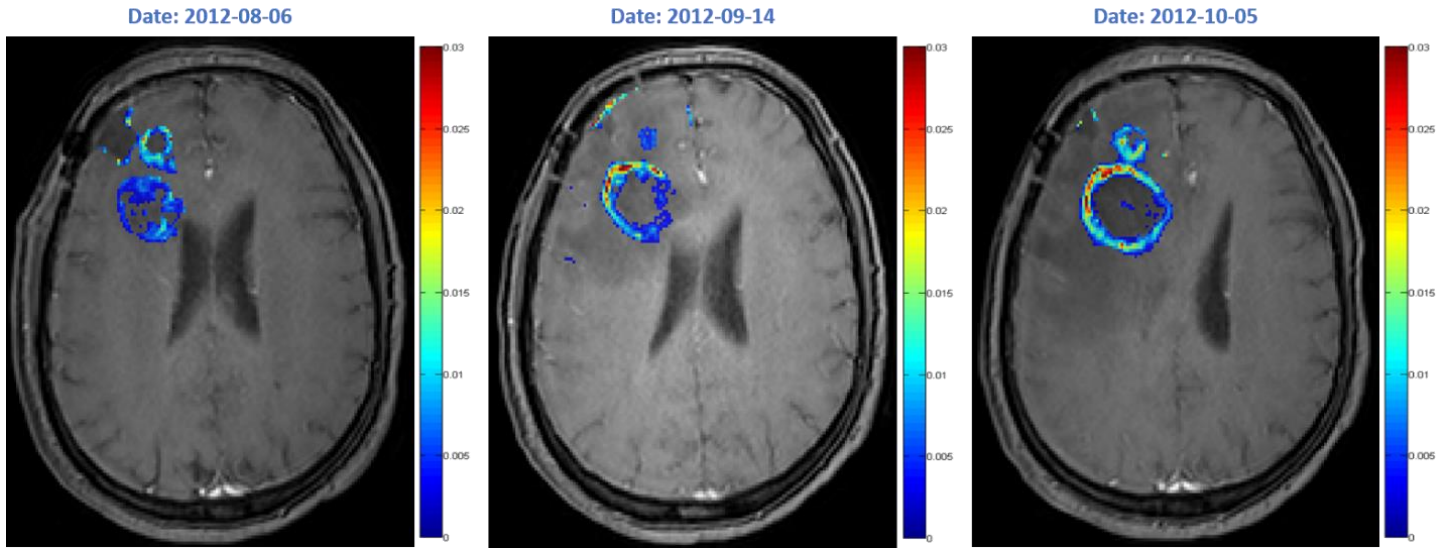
Figure 18_ The three DCE-MR images; the diagnostic and the two FUs sessions. The FU2 was not used in our approximation as a second validation point.
